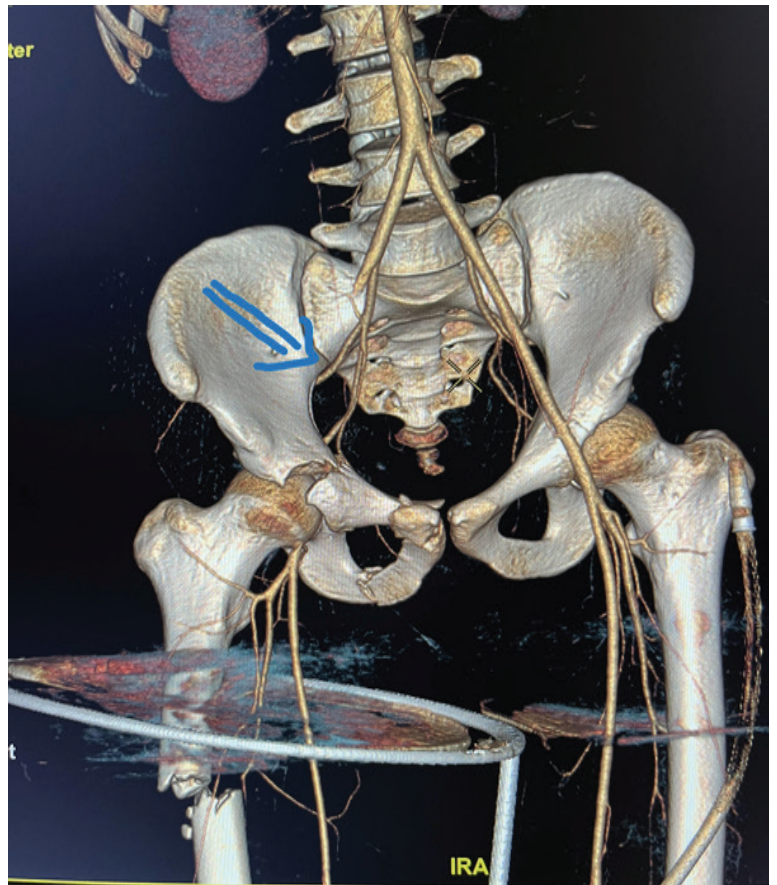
CT showing acetabular fracture (anterior column) right side with external iliac artery complete cutoff (occlusion). Right femur shaft fracture is also evident.
